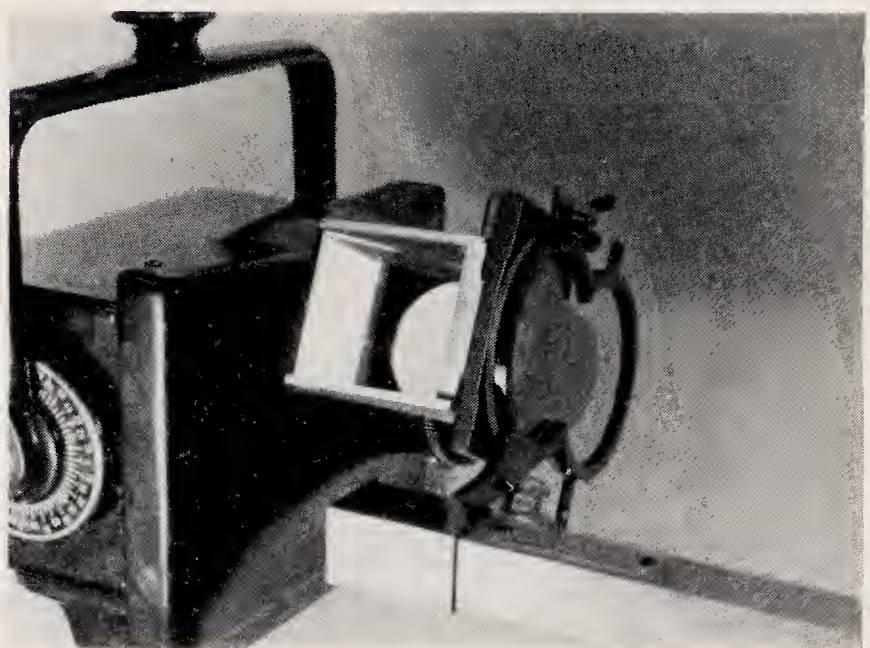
X-ray tube end of craniostat showing mirror for observation of patient's posture.
